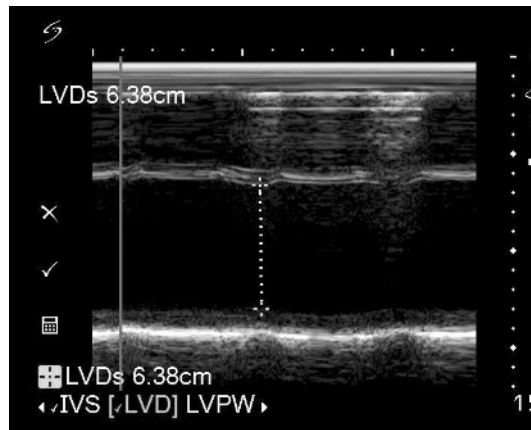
M mode echocardiogram showing a dilated left ventricle (6.38 cm in systole) of a patient with severe Chagas cardiomyopathy, with pronounced hypokinesia of the thinned septum and posterior wall.
